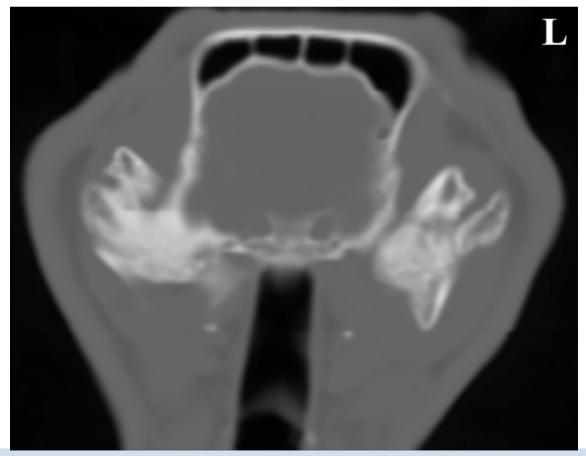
Case 2, non-contrast transverse CT scan showing deformational abnormalities in both TMJs. In both TMJs, it was observed that there was no dark line representing the normal joint space and osseous fusion was formed in the joint spaces. The mandibular fossa of the temporal bones and the condyloid processes of the mandible were extremely misshapen and thickened with irregular bone proliferation (L: left).
